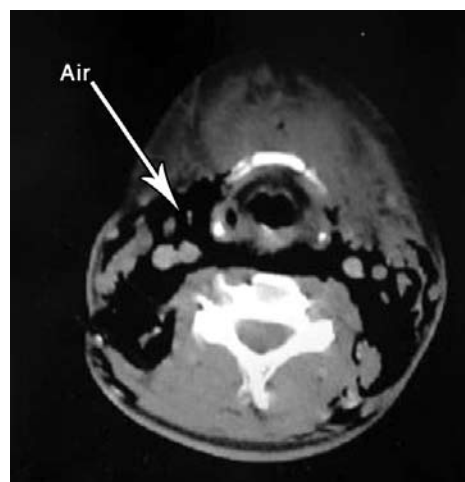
Axial CT neck shows air between the neck spaces.
